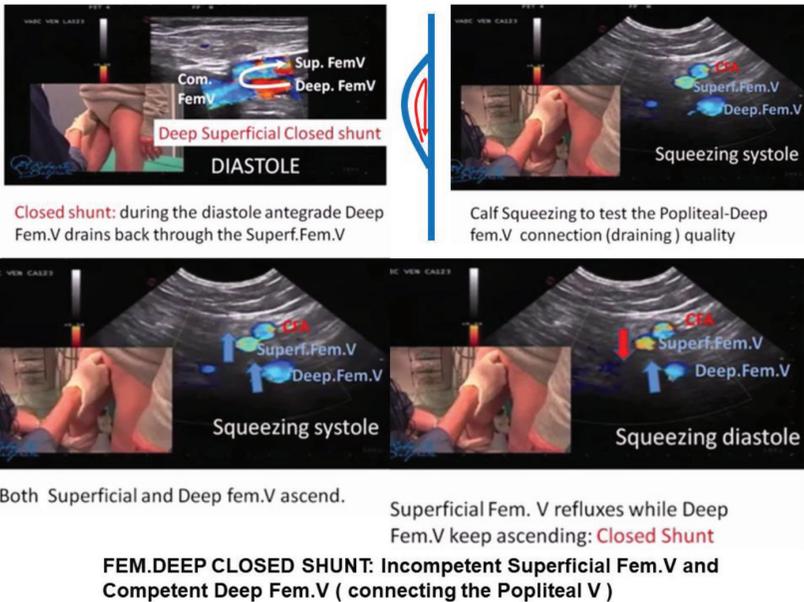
Deep Femoral Closed shunt assessment with Duplex ultrasound.
